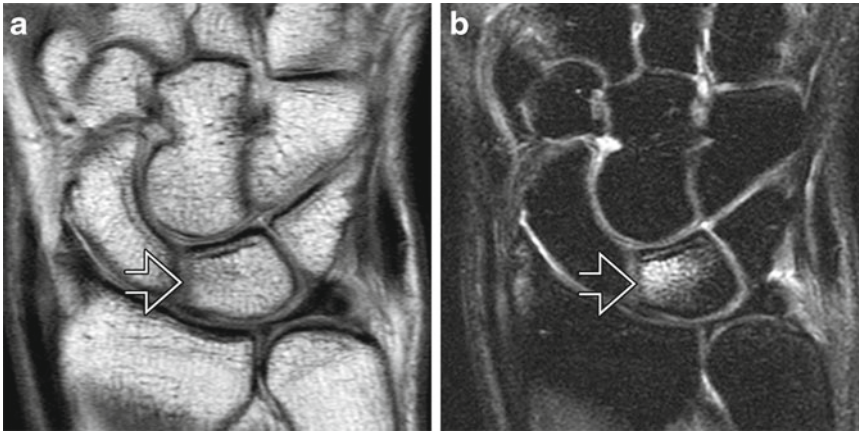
Lunate contusion. (a) Coronal T1-weighted MR image shows only subtle hypointensity in the lunate (*arrow*). (b) Coronal T2-weighted fat-suppressed MR image shows relatively diffuse increased signal in the lunate (*arrow*)
